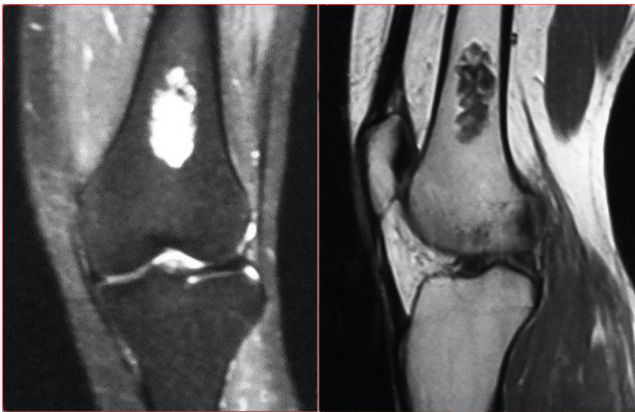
Preoperative coronal and sagittal MRI views of the lesion
